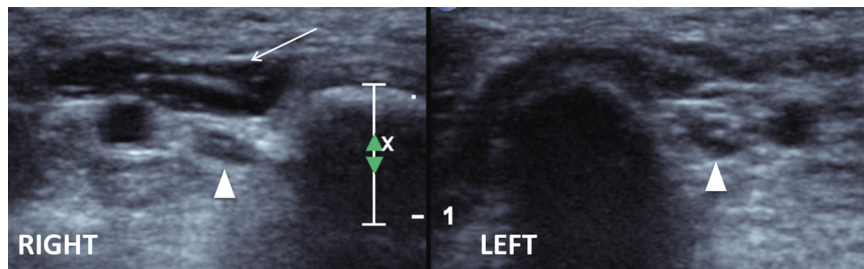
Comparative ultrasound appearance of right and left Guyon's tunnels showing an asymptomatic accessory 5th finger abductor muscle (white arrow) on the right, with no compression of the ulnar nerve (arrowhead), discovered fortuitously.
